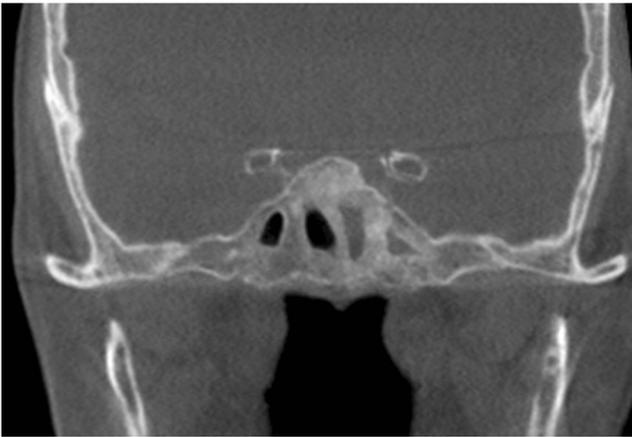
CT scan image of osteitis. mm: millimeter
